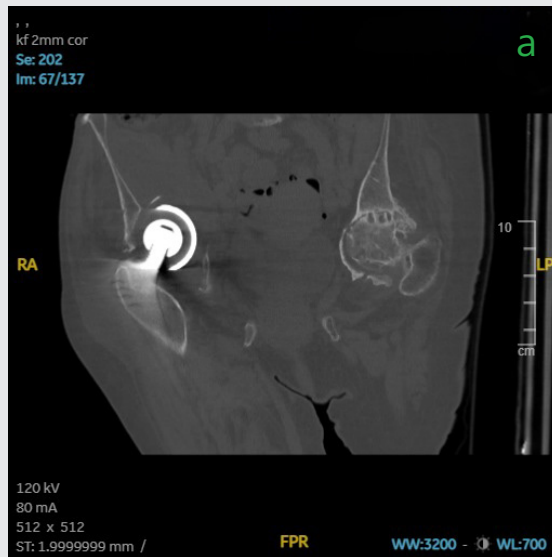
to c Preoperative CT imaging in the frontal plane (a) and sagittal plane (b, c)
